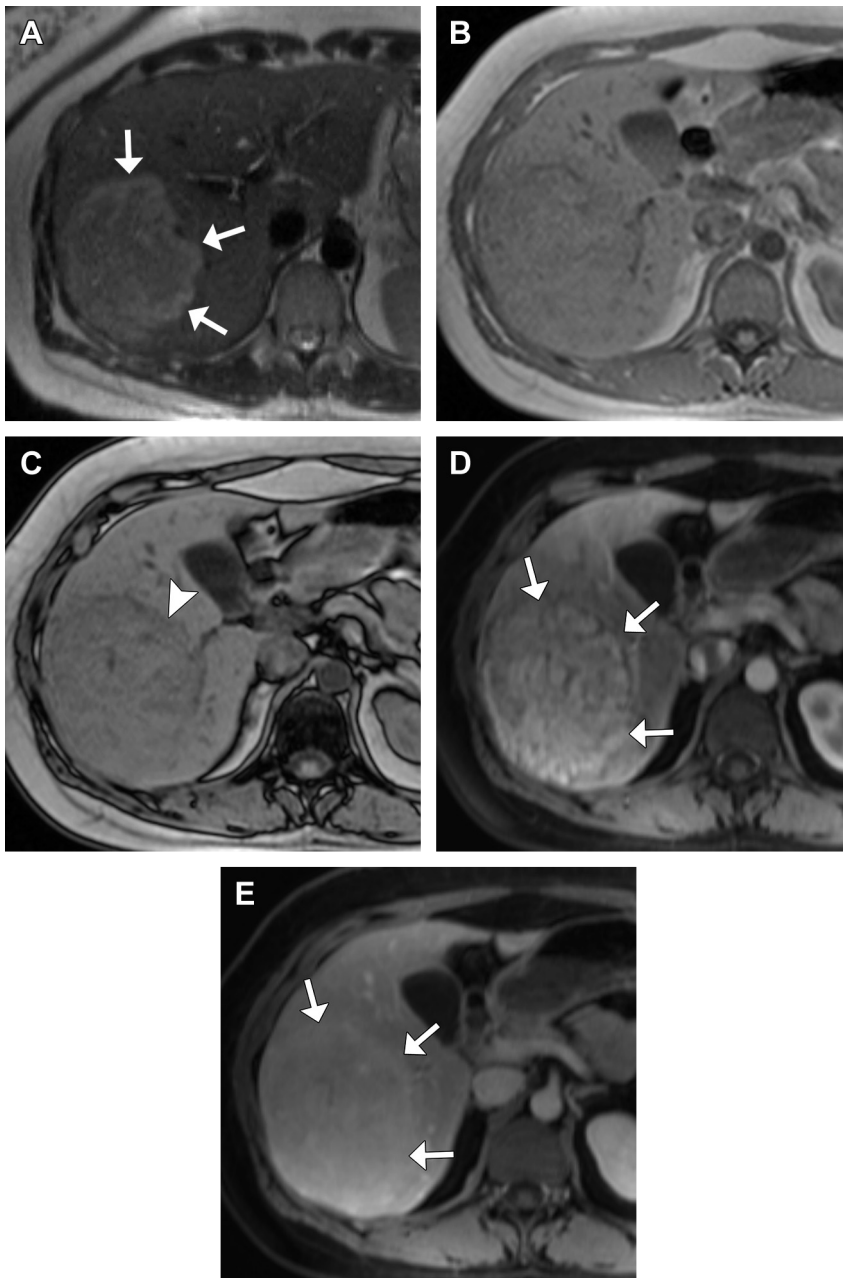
HCA (inflammatory subtype): “atoll sign.” (A) Large right hepatic mass exhibits a peripheral ringlike band of T2 hyperintense signal (arrows) and less pronounced mildly T2 hyperintense signal centrally, with overall appearance likened to a coral atoll. (B) The mass is nearly isointense to liver on in-phase T1-weighted imaging. (C) There is subtle signal loss on opposed-phase T1-weighted imaging suggesting intracellular fat (arrowhead), although not as pronounced or diffuse as described with HNF-1 α -inactivated subtype. (D, E) Postcontrast images demonstrate arterial hyperenhancement that persists on delayed imaging (arrows). Inflammatory HCA was found at resection.
